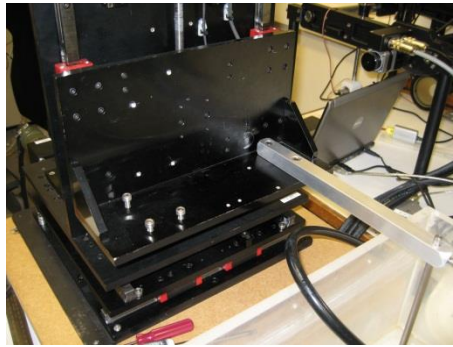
Radiotherapy Platform used to move the ultrasound transducer automatically and precisely from well to well.
